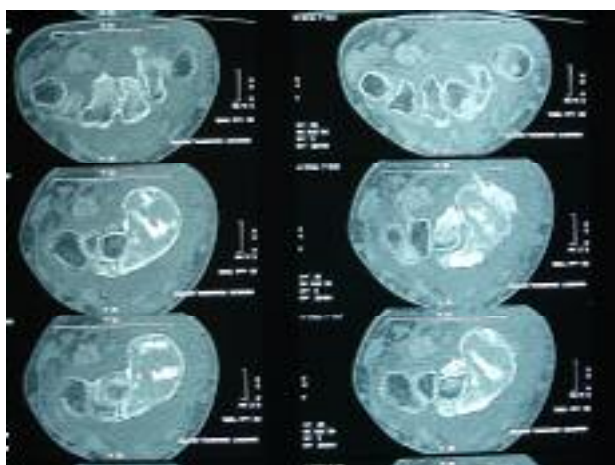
CT Scan of the wrist, axial view
